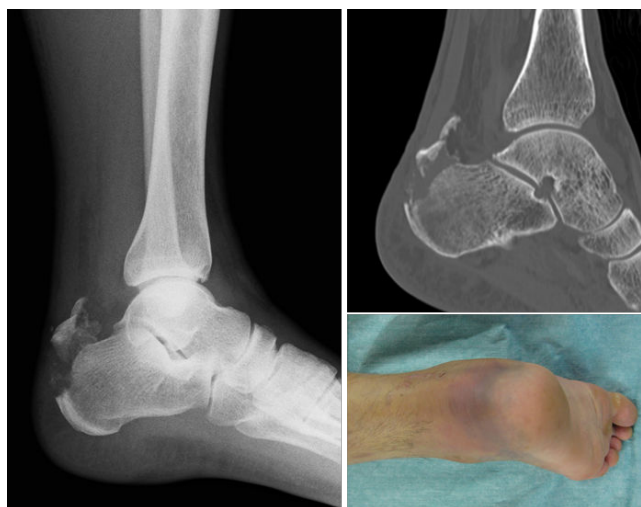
A plain radiograph (left hand panel) and computed tomography image (upper right) demonstrating a type I calcaneal avulsion fracture. The skin condition was acceptable at the time of surgery (lower right), 3 days after the trauma.
